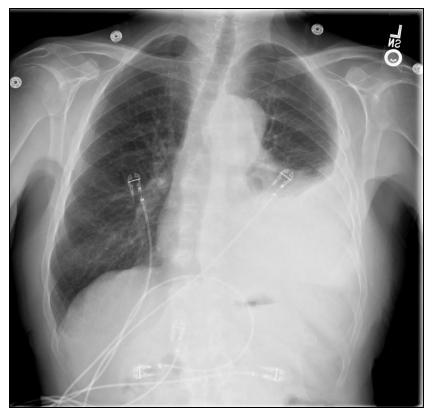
Chest x-ray exhibiting decrease in size of left-sided pleural effusion following US-guided thoracentesis.
